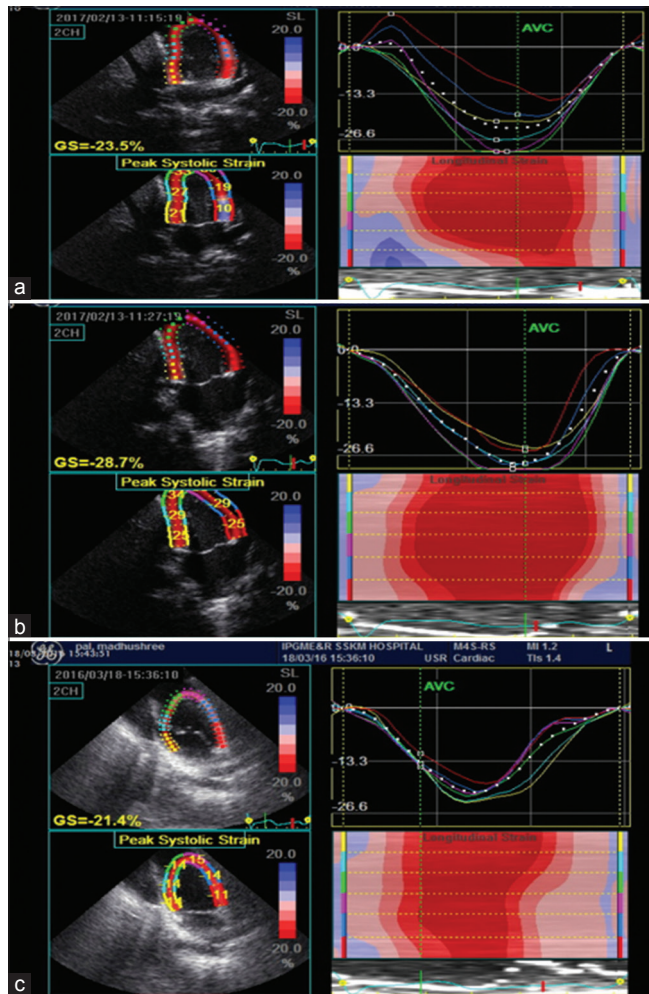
(a) Global longitudinal strain imaging of Left ventricle in patient of atrial septal defect before correction. Apical 4-chamber view is shown. Red, white, and blue line represent different segment of the left ventricle while dotted lines represents global longitudinal strain. (b) Global longitudinal strain imaging of right ventricle in patient of atrial septal defect before correction. Apical 4-chamber view is shown. Red, white, and blue line represent different segment of the right ventricle while dotted lines represents global longitudinal strain. (c) Global longitudinal strain imaging of right ventricle in patient of atrial septal defect after correction. Apical 4-chamber view is shown. Red, white, and blue line represent different segment of right ventricle while dotted lines represents global longitudinal strain
